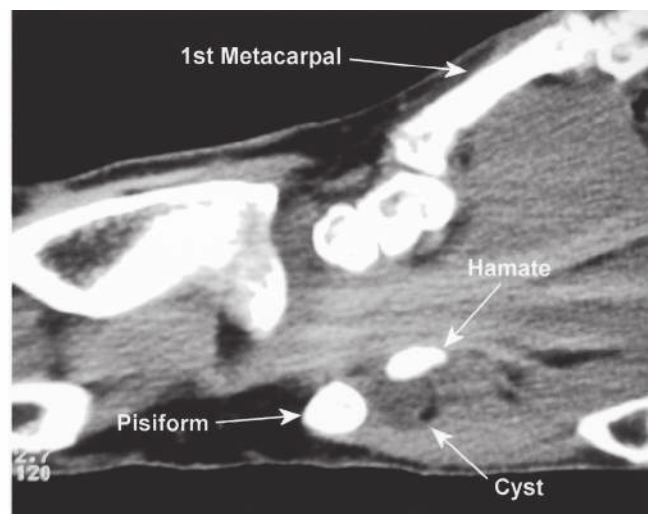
Ganglion cyst in Guyon's canal. One of the more common causes of ulnar neuropathy at the wrist is compression of the ulnar nerve by a ganglion cyst. Computed tomographic scan of the wrist. Left: Axial scan, volar side up. Note the cyst medial to the hook of the hamate. Right: Coronal scan, lateral hand up. Note the cyst between the pisiform and the hamate.
